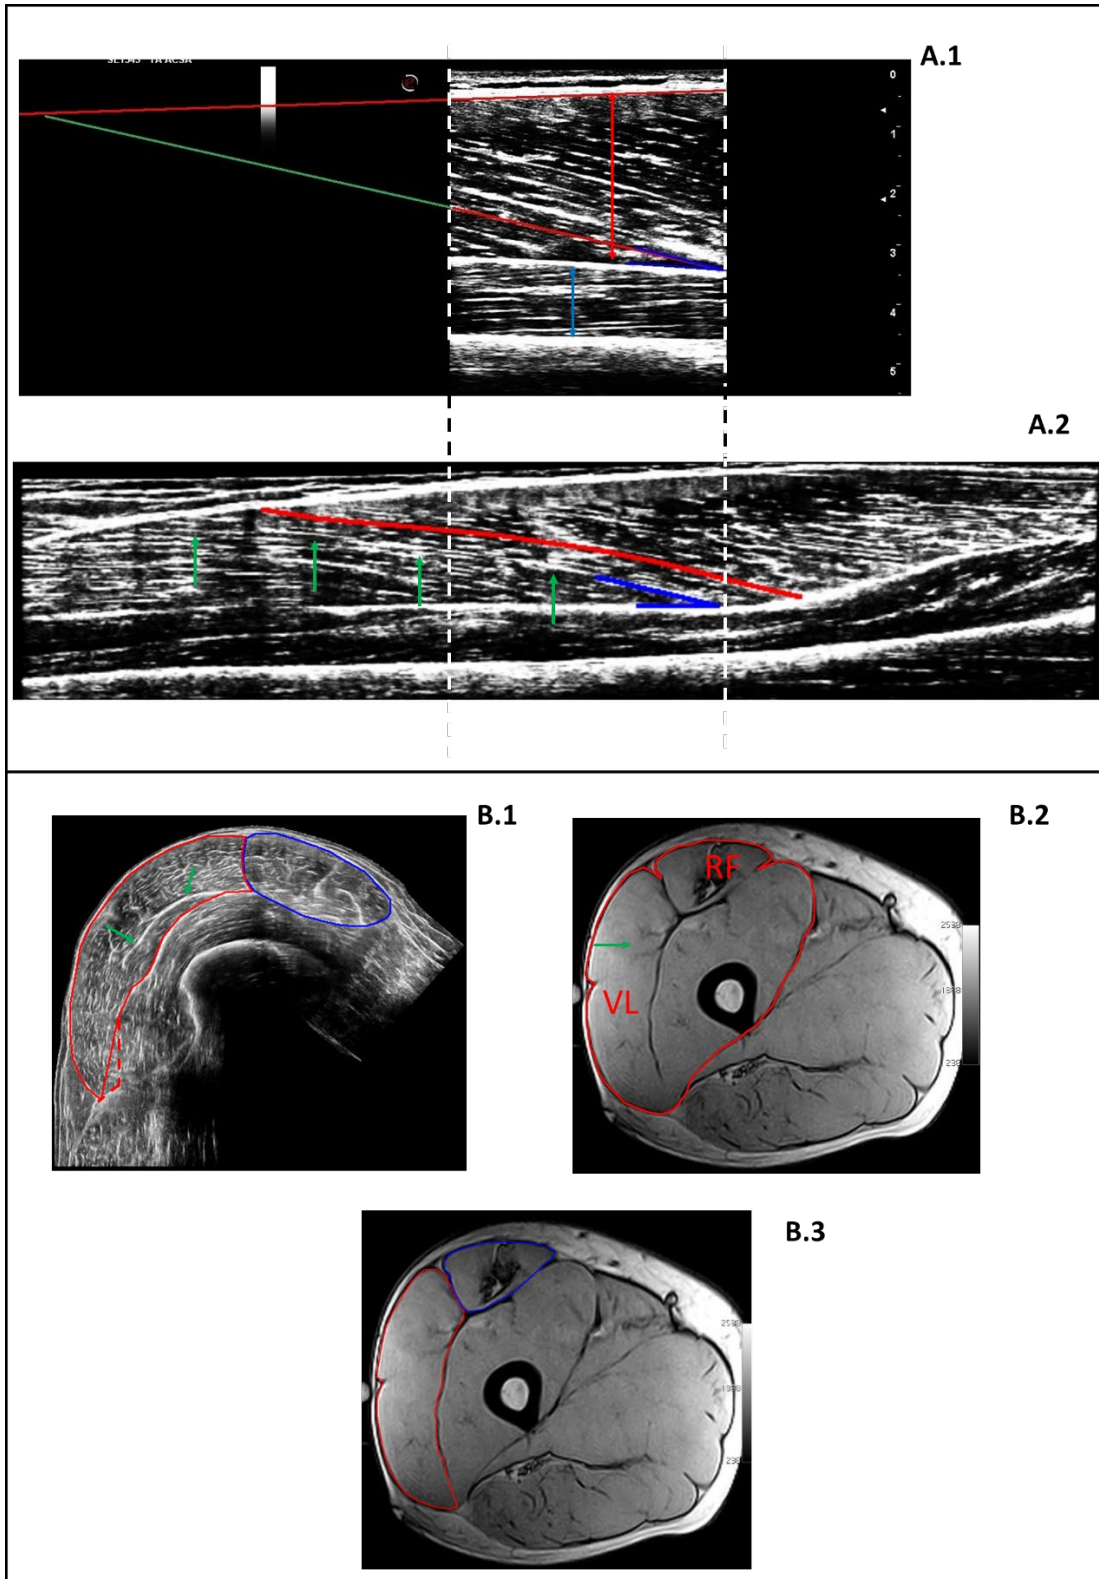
Ultrasound (A.1, A.2, B.1) and magnetic resonance (B.2) Images of Vastus Lateralis, Vastus Intermedius and Rectus Femoris.
